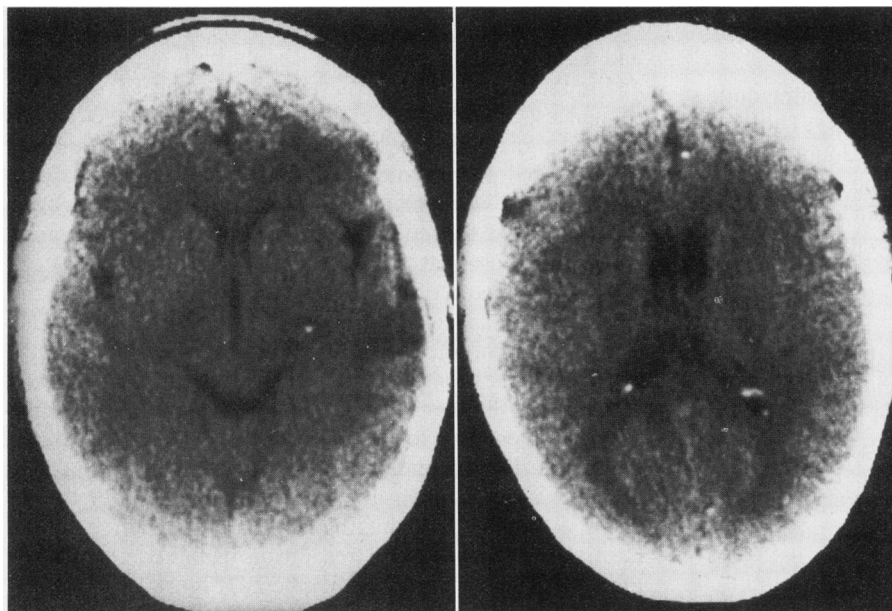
Patient 1. Non-contrast computed tomographic scan showing edema in both parietal lobes (left and right). Additionally, a punctuate calcification with surrounding edema is seen in the left basal ganglia region (left).
